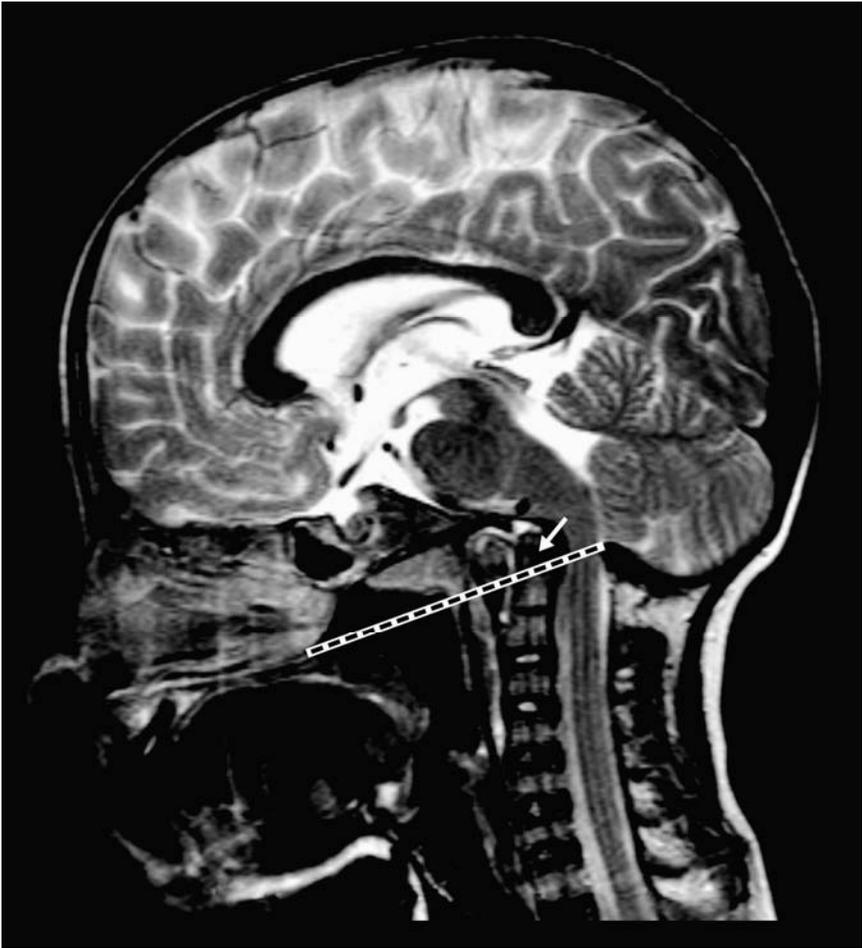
Basilar impression on brain MRI. The tip of the odontoid process (arrow) projects > 5 mm above Chamberlain (line between the hard palate and the opisthion which is the mid-point on the posterior margin of the foramen magnum). Adapted from Eaqeib et al.¹⁷
